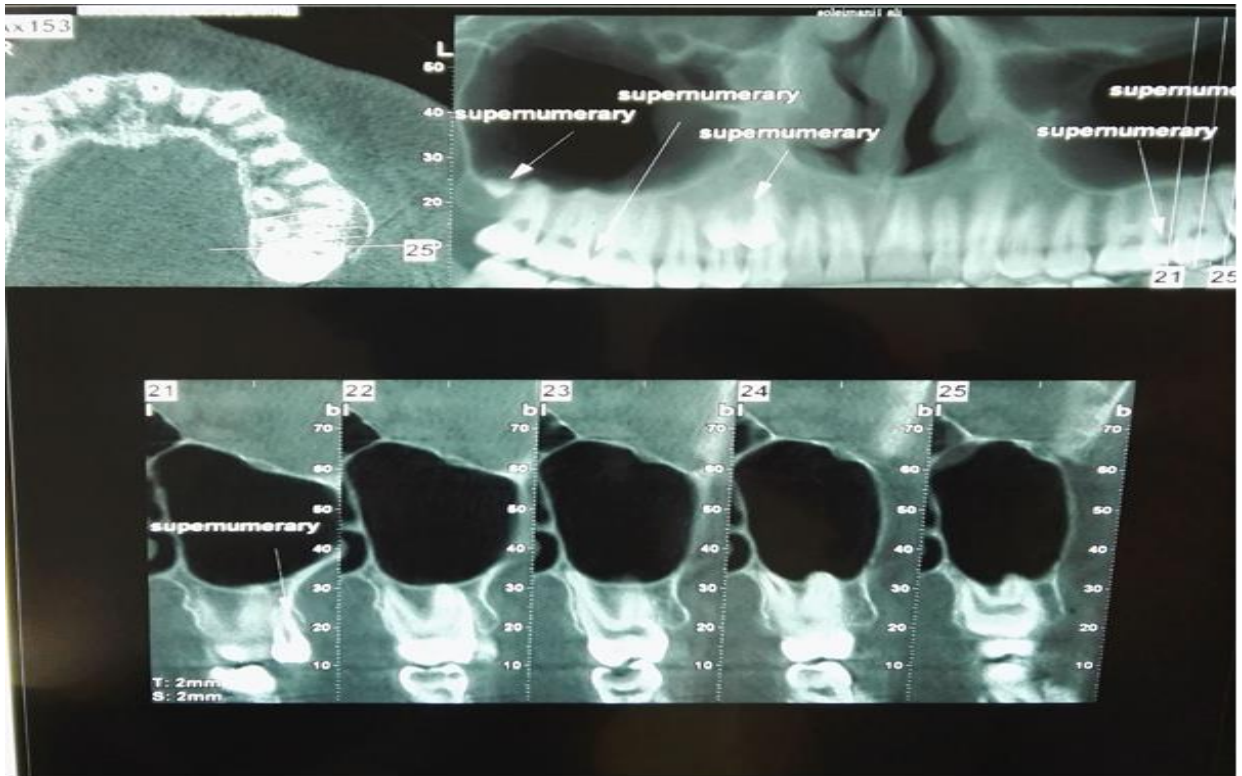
Axial, cropped reconstructed panoramic and cross sectional CBCT views of the maxilla
